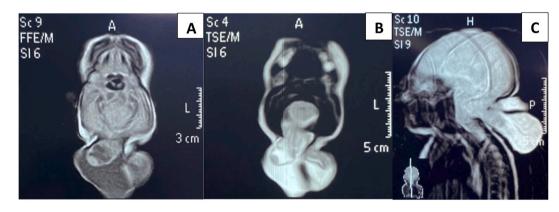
Computed tomography scan of the brain showing (A, B) on axial view a 30 mm defect in the occipital bone with two herniated brain tissue sacs (C) on sagittal view a defect in the occipital bone with two herniated brain tissue sacs.
